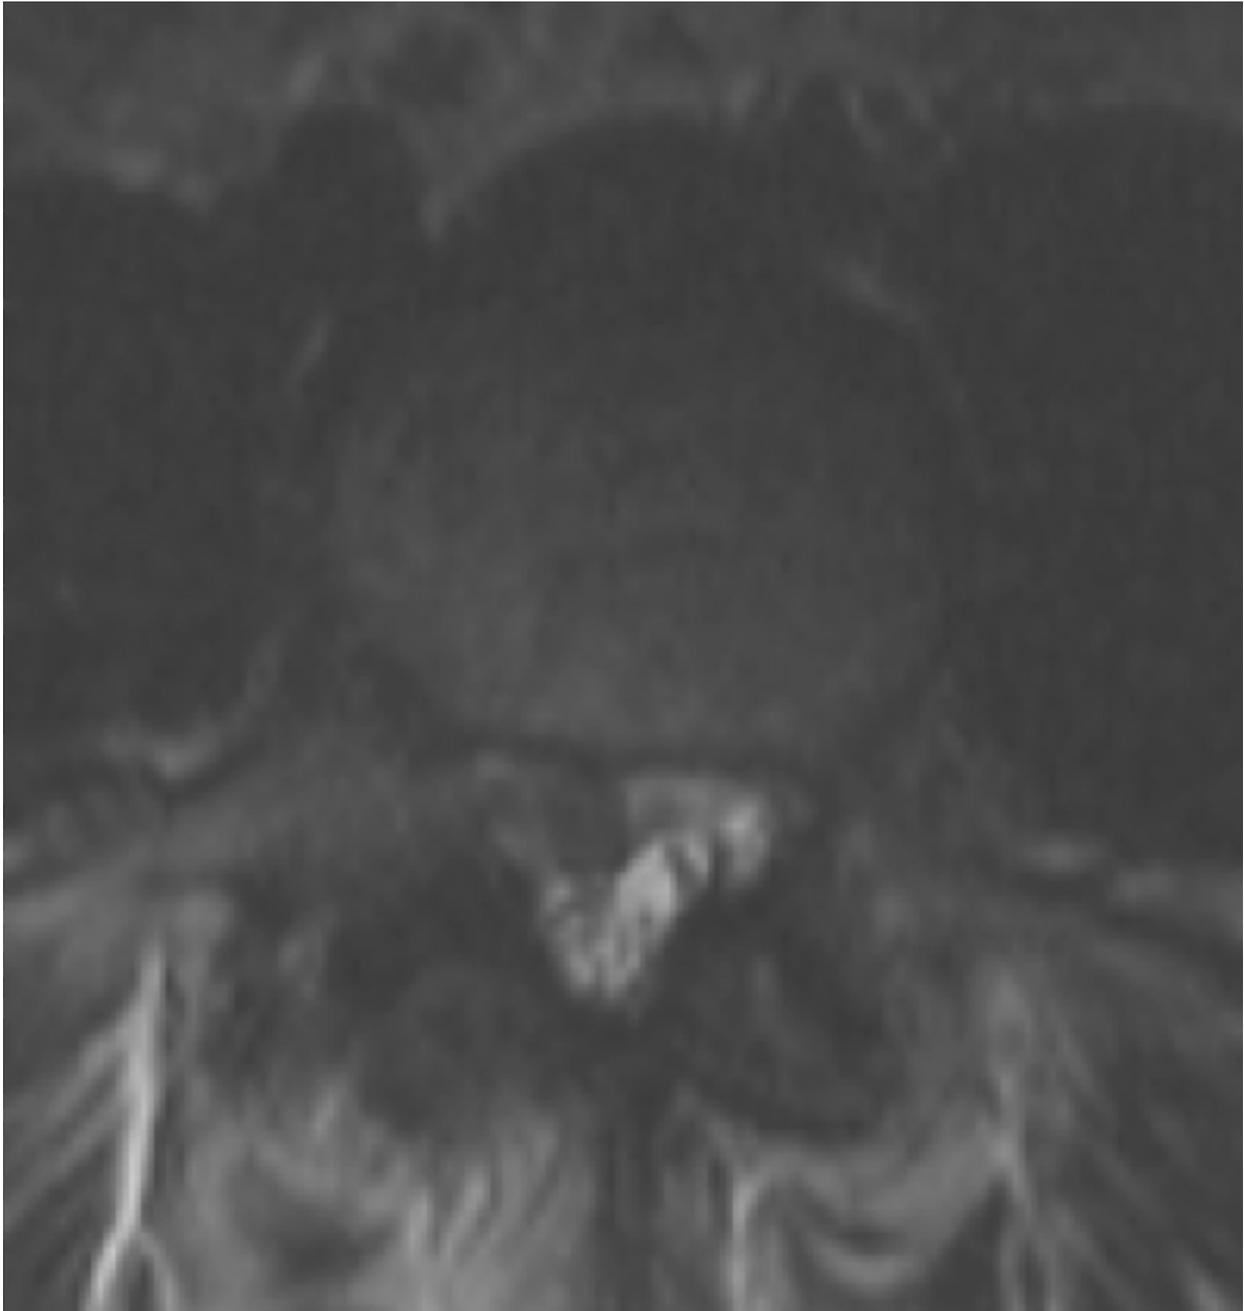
Axial T1 Weighted Lumbar Spine MRI image showing moderate size disc herniation with moderate disc compromise.
